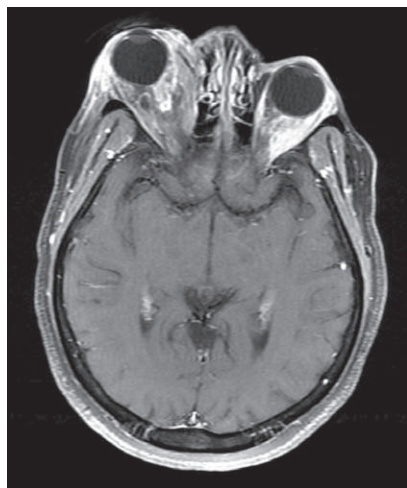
MRI orbits with gadolinium contrast. T1-weighted axial view demonstrating extensive infiltration of the right orbit.
